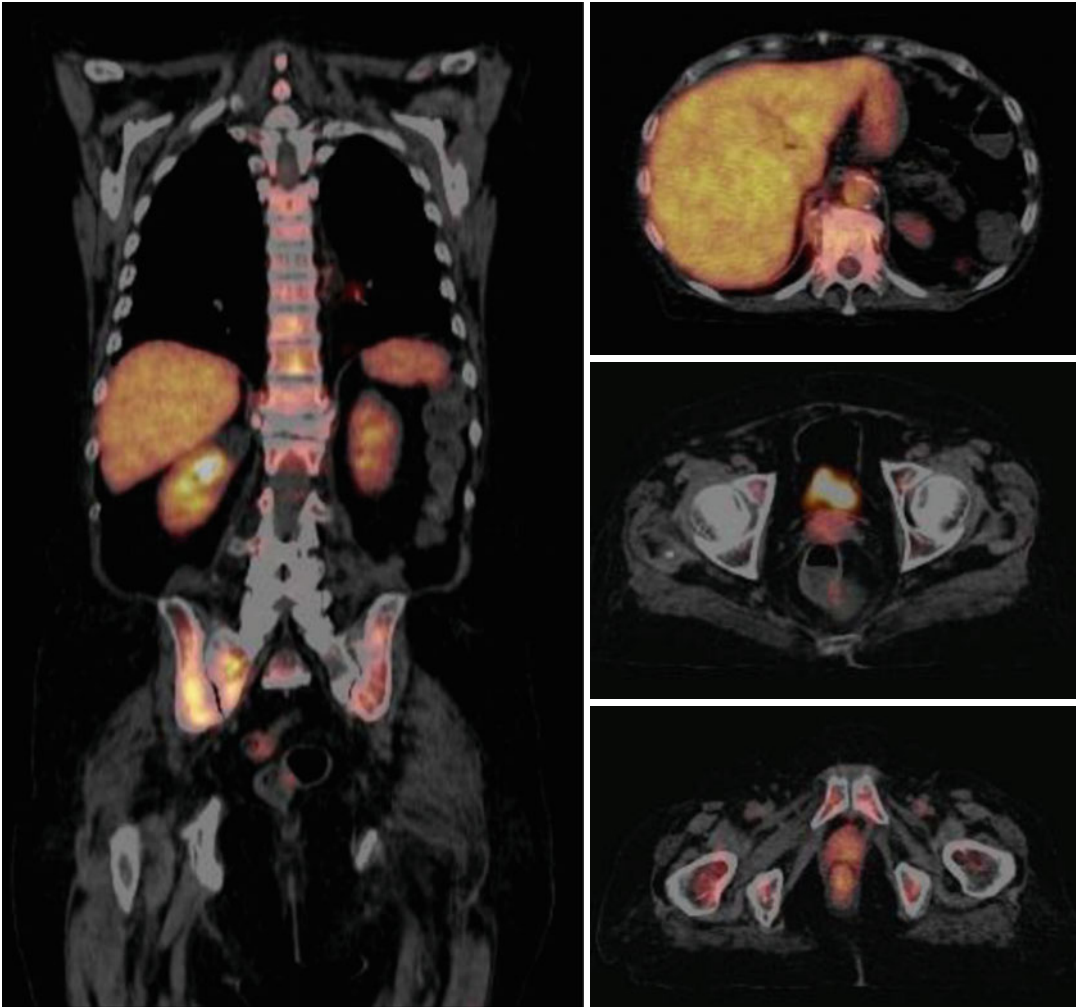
FDG PET/CT – interim: No abnormal FDG uptake is shown in lymph nodes. FDG activity in cervical, thoracic, and lumbar vertebrae is lower, compared to the previous PET/CT scan
